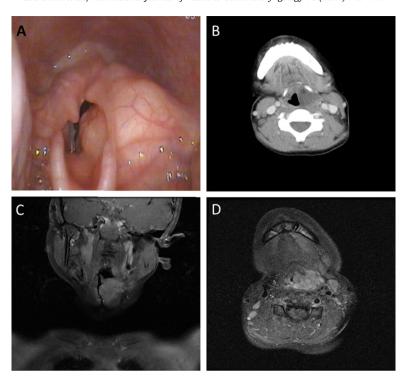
(A) Pre-operative office-based flexible laryngoscopy demonstrating a large submucosal mass centered within left aryepiglottic fold with inferior extension to the false fold and lateral obliteration of the adjacent piriform sinus. (B) Axial CT-scan with contrast. (C) Representative coronal. (D) Axial MRI images.
